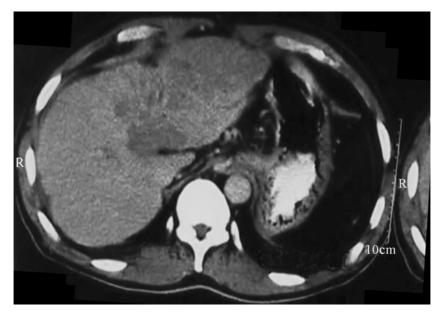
CT showing tumor in the caudate lobe and the left lobe
